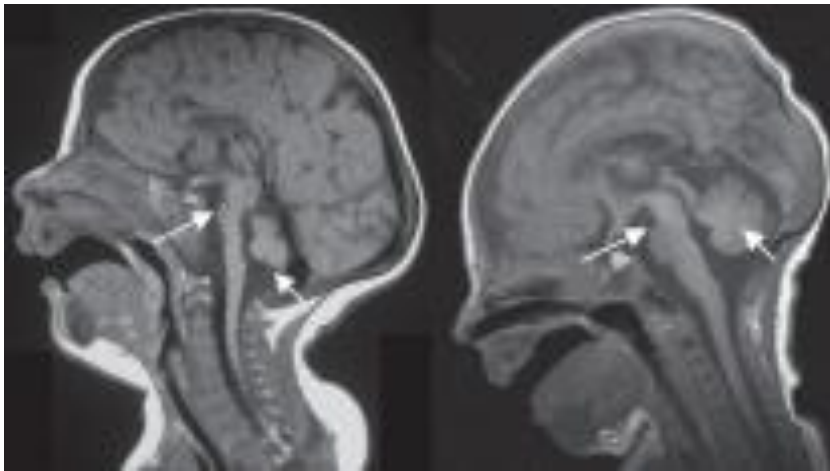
Magnetic resonance image of a PCH2 child (left) compared to a normal child (right). Arrows show the thinning of the bridge and the cerebellar vermis (short arrows).
